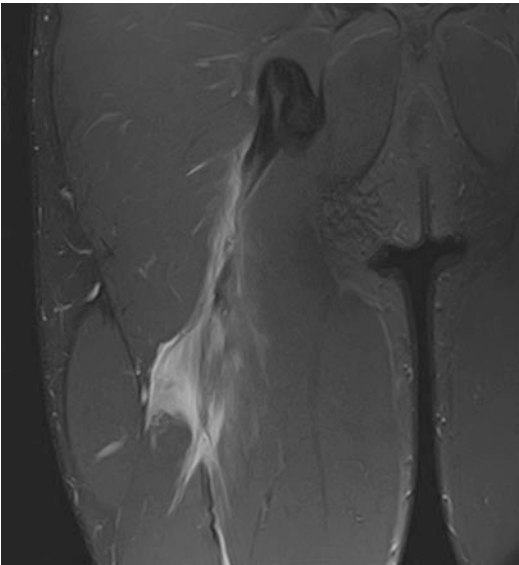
An MRI of a proximal biceps femoris rupture
